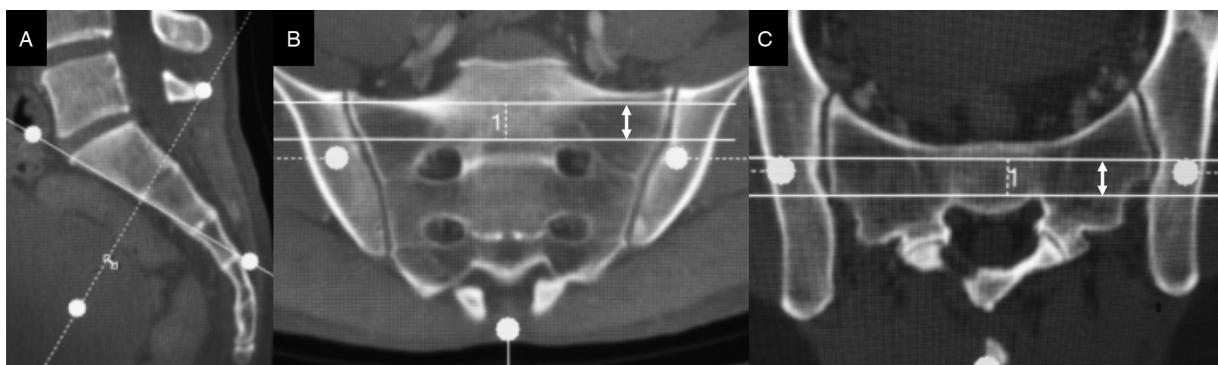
(A–C) Measurement of the horizontal corridor in the upper sacral segment on reconstructed CT images. As the standard axis was aligned with the anterior cortex in the mid-sagittal section (A), the true coronal images (B), and the true axial images (C), which were parallel and perpendicular, respectively, to the standard axis, were displayed automatically. On true coronal and true axial images, a corridor with the maximum width was sought while avoiding screw penetration outside the intraosseous corridor. The width on each plane was recorded (B and C, double-headed arrows). The same measurement was performed for the second and third horizontal corridors.
